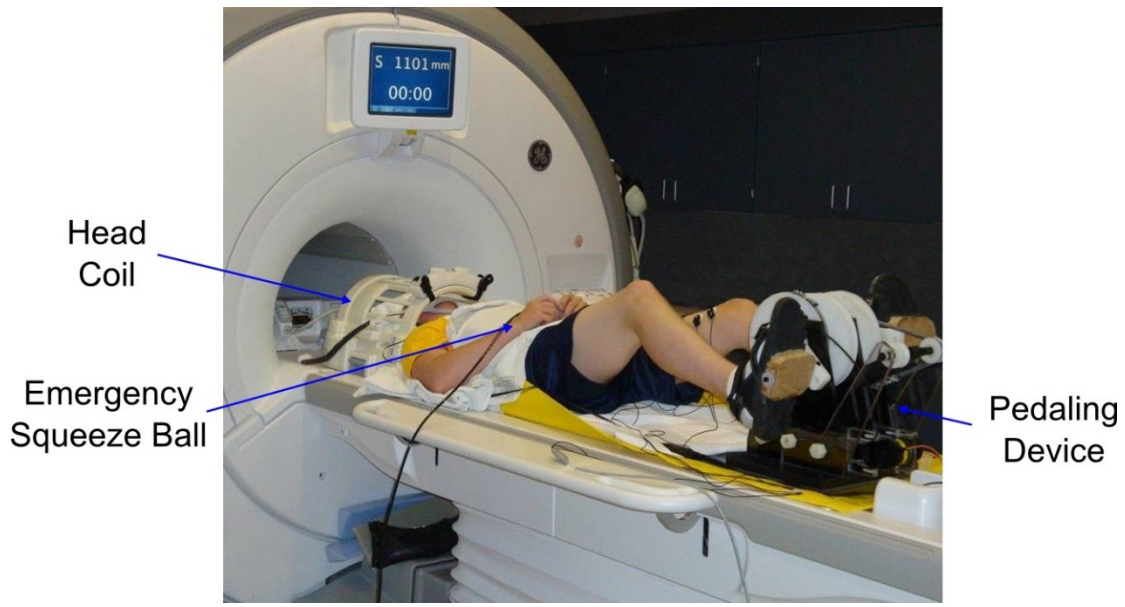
Experimental setup for MRI sessions. Subject lies supine on the MRI scanner bed with feet strapped to the device pedals. A backboard runs under the subject to stabilize the device, straps and padding are used to limit head movement of the subject.
